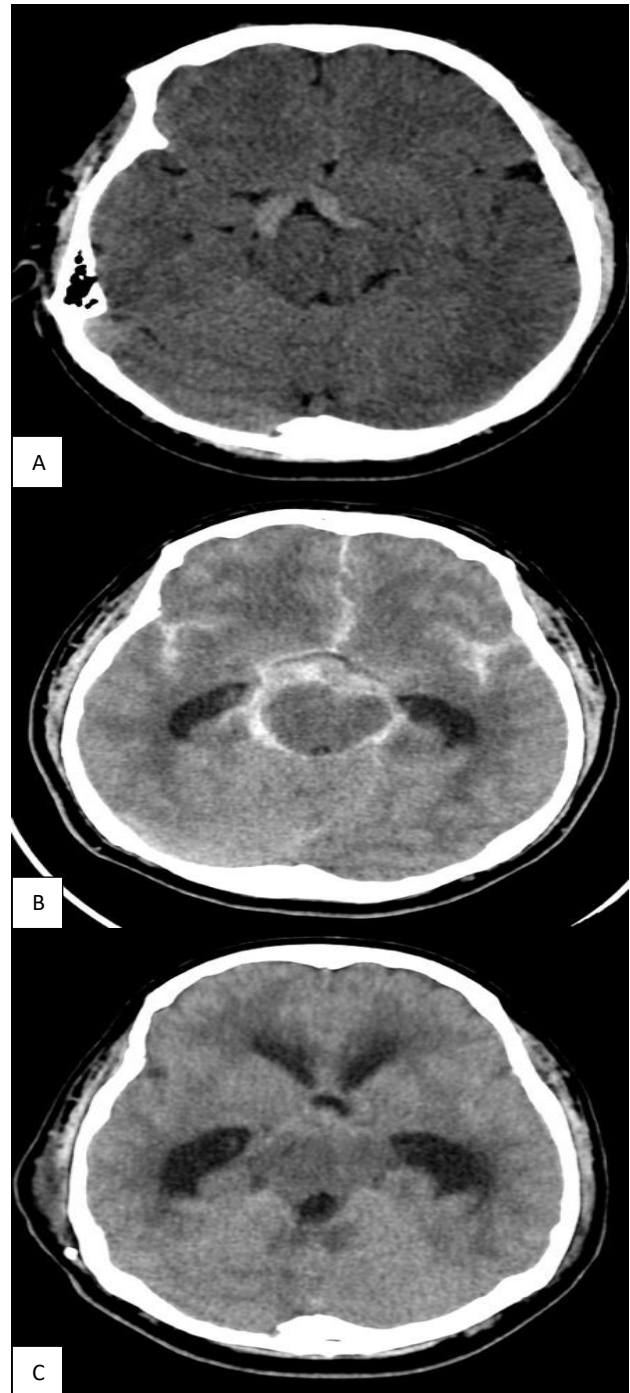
(A-C): Brain CT scan at admission showed bilateral vertebral artery ectasia; brain CT scan at the second day of admission showed spontaneous diffuse subarachnoid hemorrhage and brain CT scan at two weeks of admission revealed hydrocephalus.
